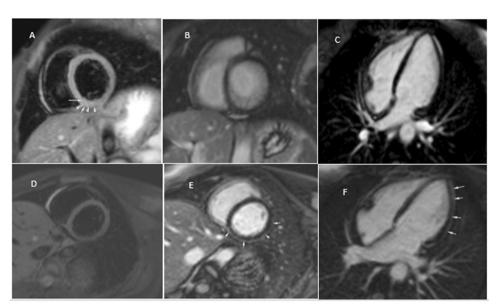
The top panel displays the initial MRI images, while the bottom panel shows the MRI scans taken 8 months later. (A)short-axis view, T2 Weighted Image, showed myocardial edema present in the basal inferior septal LV segment, (B, C) in the short-axis and 4ch view, there was no evidence of late gadolinium enhancement, (D)another short-axis view with a T2 Weighted Image, showed improvement in myocardial inflammation, (E, F), late enhancement images revealed evidence of sub-epicardial fibrosis in the basal to mid inferior, inferior lateral and anterior lateral LV segments, which suggest the presence of post myocarditis scar.
